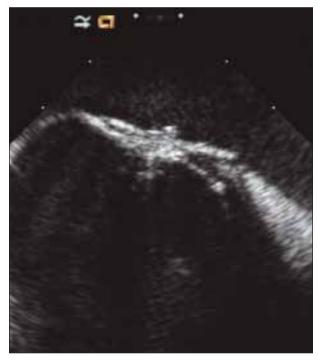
The Gore Helex Septal occluder device by intracardiac echocardiography 6 months after implantation.
